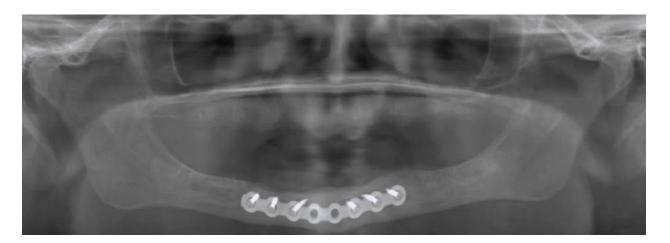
Radiographic image 4.5 months after ViviGen Formable implantation showing new bone formation at the graft site.
